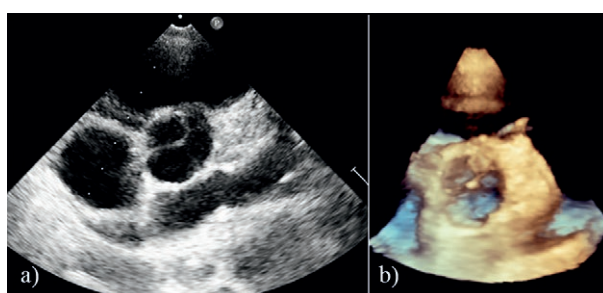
a) Transthoracic echocardiographic study showing the QAV of case 3, B type; b) 3D echocardiographic reconstruction of the QAV.
